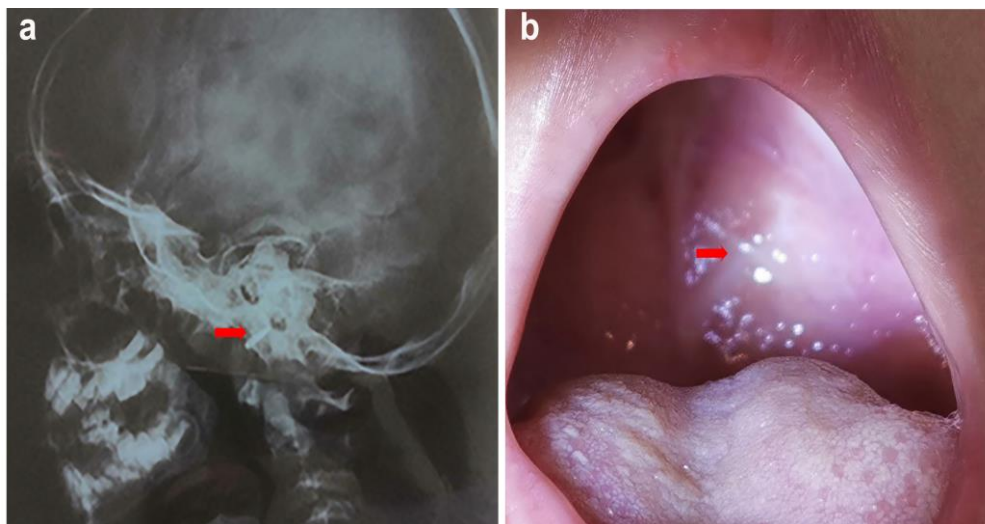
A: A conventional X-ray radiograph displaying a high-density foreign body inserted into the Occipital clivus (arrow). B, A picture of a scar in the patient's soft palate (arrow).
